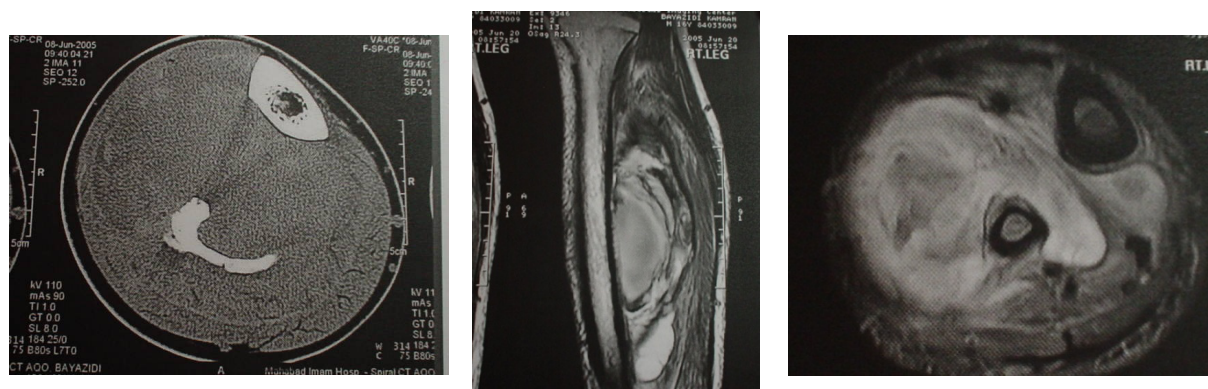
CT scanning of the leg also showed surface changes in the fibula and destructive bone lesion in that area
